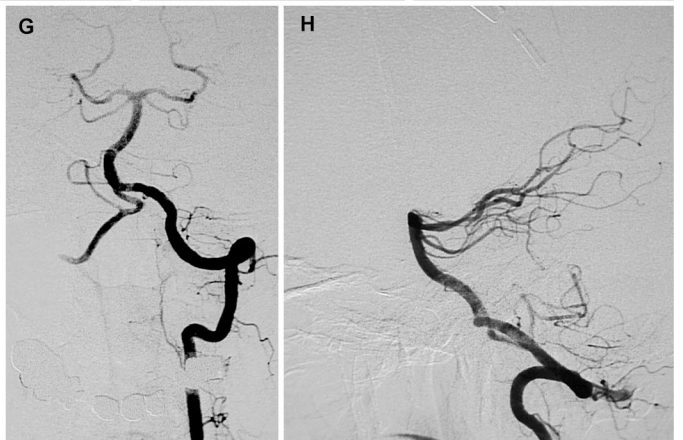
Images obtained from a 56-year-old woman with progressive diplopia and brainstem compression. A and B, anteroposterior and lateral views of left vertebral artery angiograms demonstrating distal left vertebral giant aneurysm. C, preoperative T2-weighted magnetic resonance imaging scans demonstrating brainstem compression. D, lateral view of left vertebral artery angiograms demonstrating focused jet of flow after placement of a single balloon-mounted stent. E, CT images obtained 5 days later demonstrating diffuse subarachnoid hemorrhage. F, multiple angiograms in oblique views demonstrating minimal filling of aneurysm after placement of a second balloon-mounted stent. G and H, angiograms, anteroposterior and lateral views, demonstrating complete occlusion of the aneurysm obtained at the 38-month follow-up.
